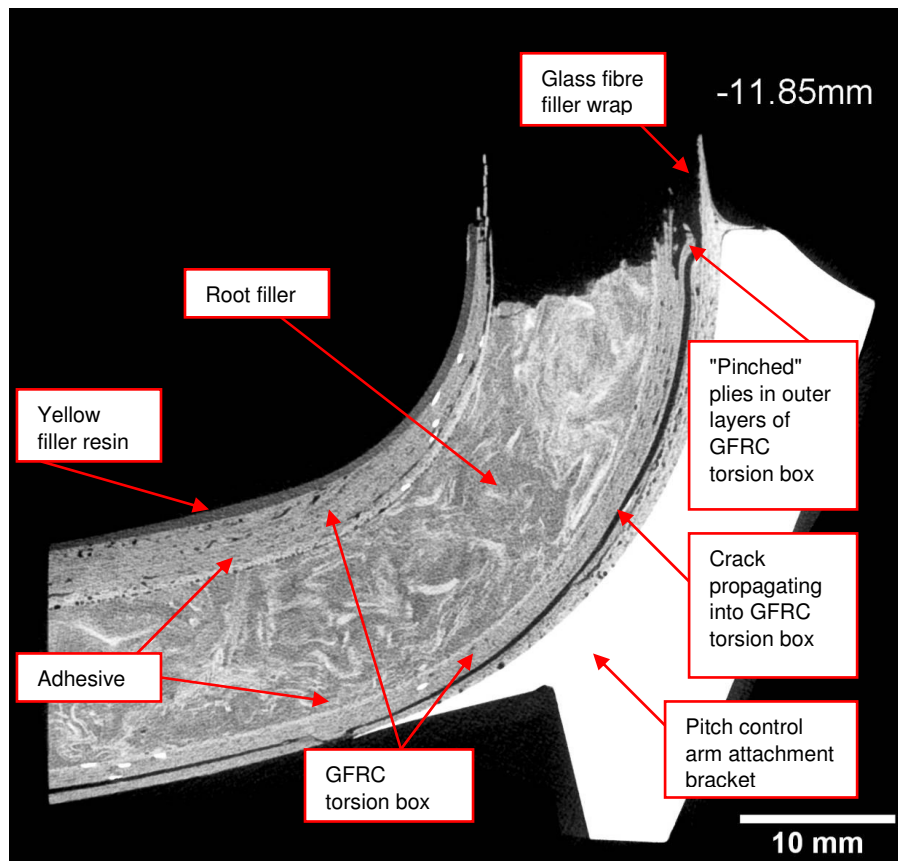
X-ray tomography image showing a side-view slice through the root filler of the White blade, trailing edge fracture location, approximately 15.4 mm from the inboard edge of the blade arm
